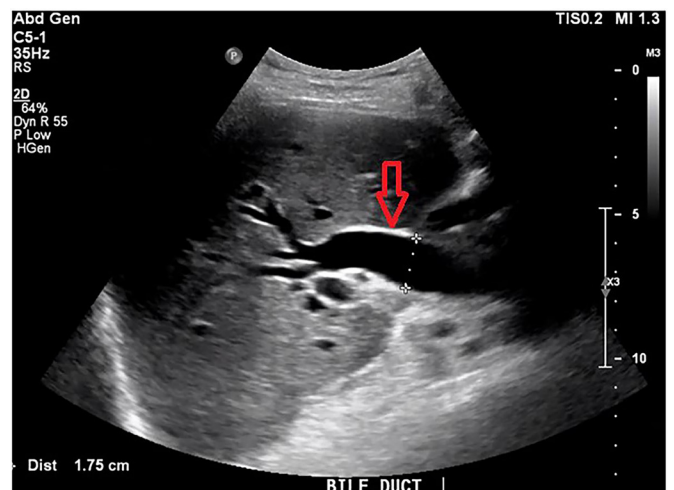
Abdominal ultrasound scan showing mild common bile duct wall thickening consistent with cholangitis (red arrow).
